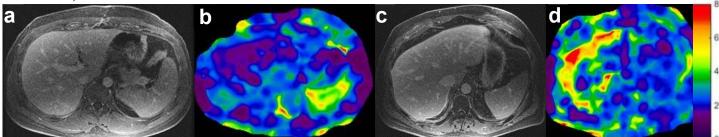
Examples of cases with and without CP. Images (a) and (b) are MRI magnitude and stiffness maps for a patient without CP. Images (c) and (d) are the corresponding images for a patient with constrictive pericarditis. The liver stiffness is elevated in the patient with CP to 5.7 kPa as InohnSared MagoriNesstiffness (2)39(2001 b) the patient without CP.
